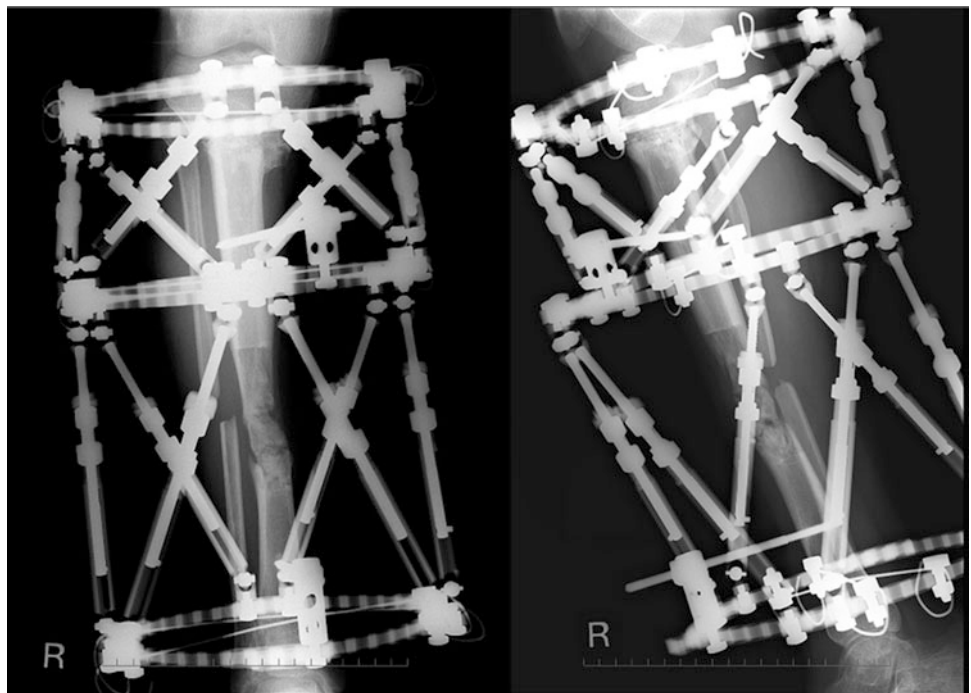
Radiographs 30 months after operation
